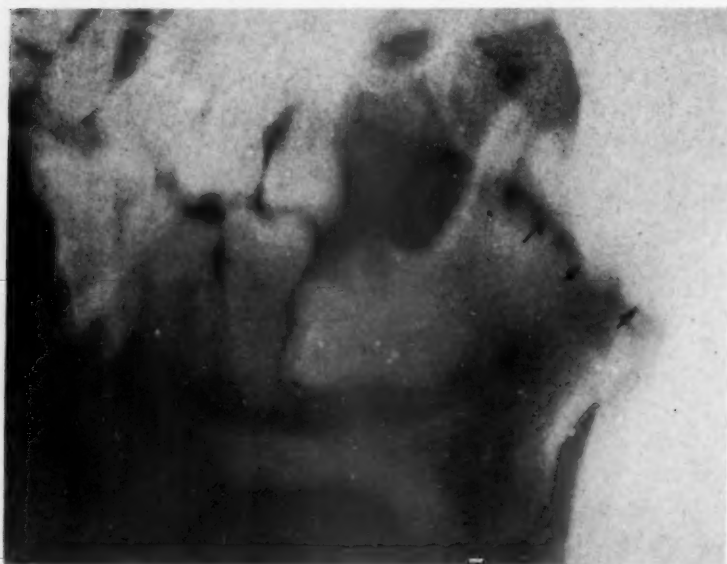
Lateral x-ray after condylectomy. Note the surface where osteotomy was performed (arrows).
